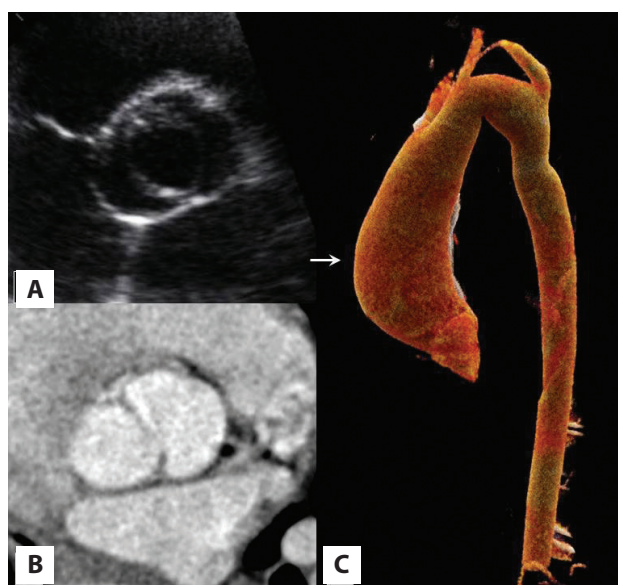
A. and B. Bicuspid aortic valve with commissure fusion between coronary cusps. Corresponding images from echocardiography and computed tomography, respectively. C. Computed tomography angiography. The white arrow indicates a dilated segment of the ascending aorta
